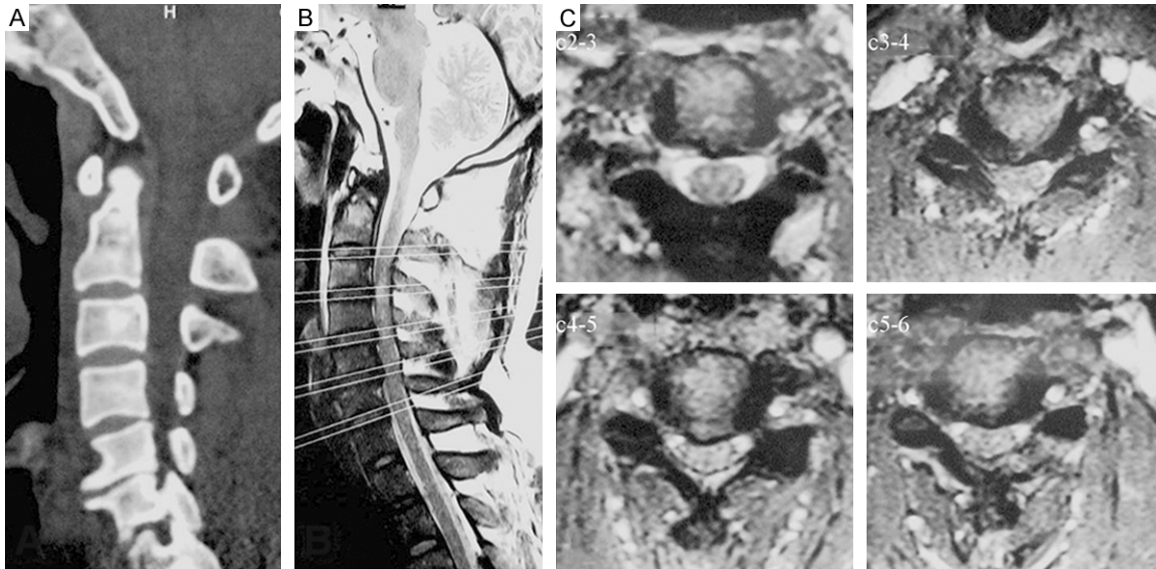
Preoperative CT did not show apparent osseous abnormalities, such as bone fractures and dislocation (A). MRI showed spinal stenosis at C3-4, C4-5, and C5-6, apparent spinal cord compression, and abnormal signals in the C3-4 spinal cord (B and C).
